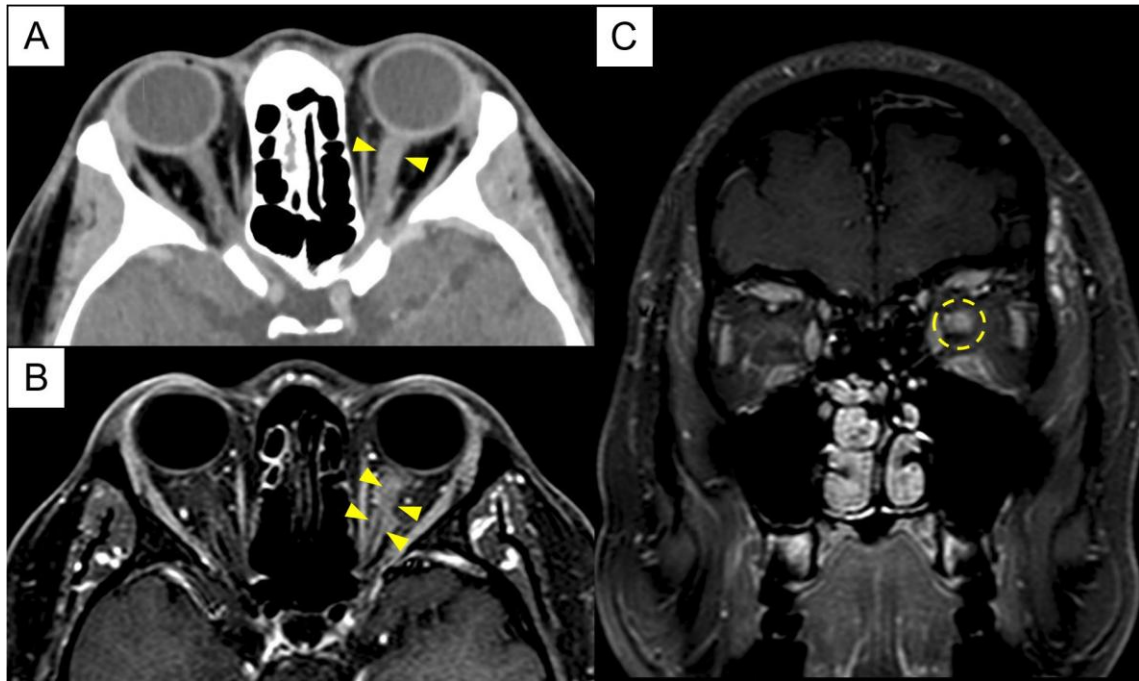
Contrasted CT in axial view (A) shows relative thickening of the left optic nerve with subtle enhancement (yellow arrowheads). The enhancement of the optic nerve sheath, resulting in the tram-track sign, is demonstrated in the T1-weighted with fat suppression (T1FS) post-contrast MRI B). On T1FS post-contrast MRI in coronal view (C), the circumferential enhancement results in the doughnut sign (yellow circle).
